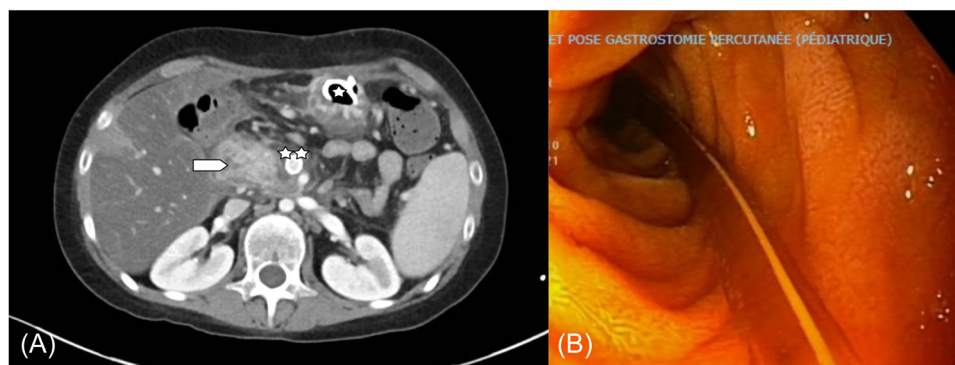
(A) MRI T2 sequence (Patient 2) showing important edema of D2 resulting in the narrowing of the bowel lumen by >90% (arrow) as evidenced on subsequent endoscopy (data not shown). The patient has a cystogastrostomy pigtail stent in place (*) and a stent was inserted in the thrombosed portal vein (stent extending in the superior mesenteric vein). (B) Follow-up endoscopy showing progressive regression of the obstruction and edema of the duodenum.
